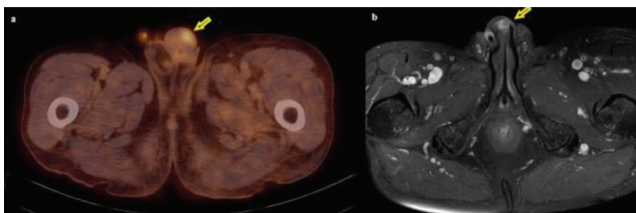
F-18 FDG PET/CT scan axial fusion image was noted lesion in the left corpus cavernosum (a: yellow arrow). Penil MRI T1 enhanced image shows metastatic lesion (b: yellow arrow)
